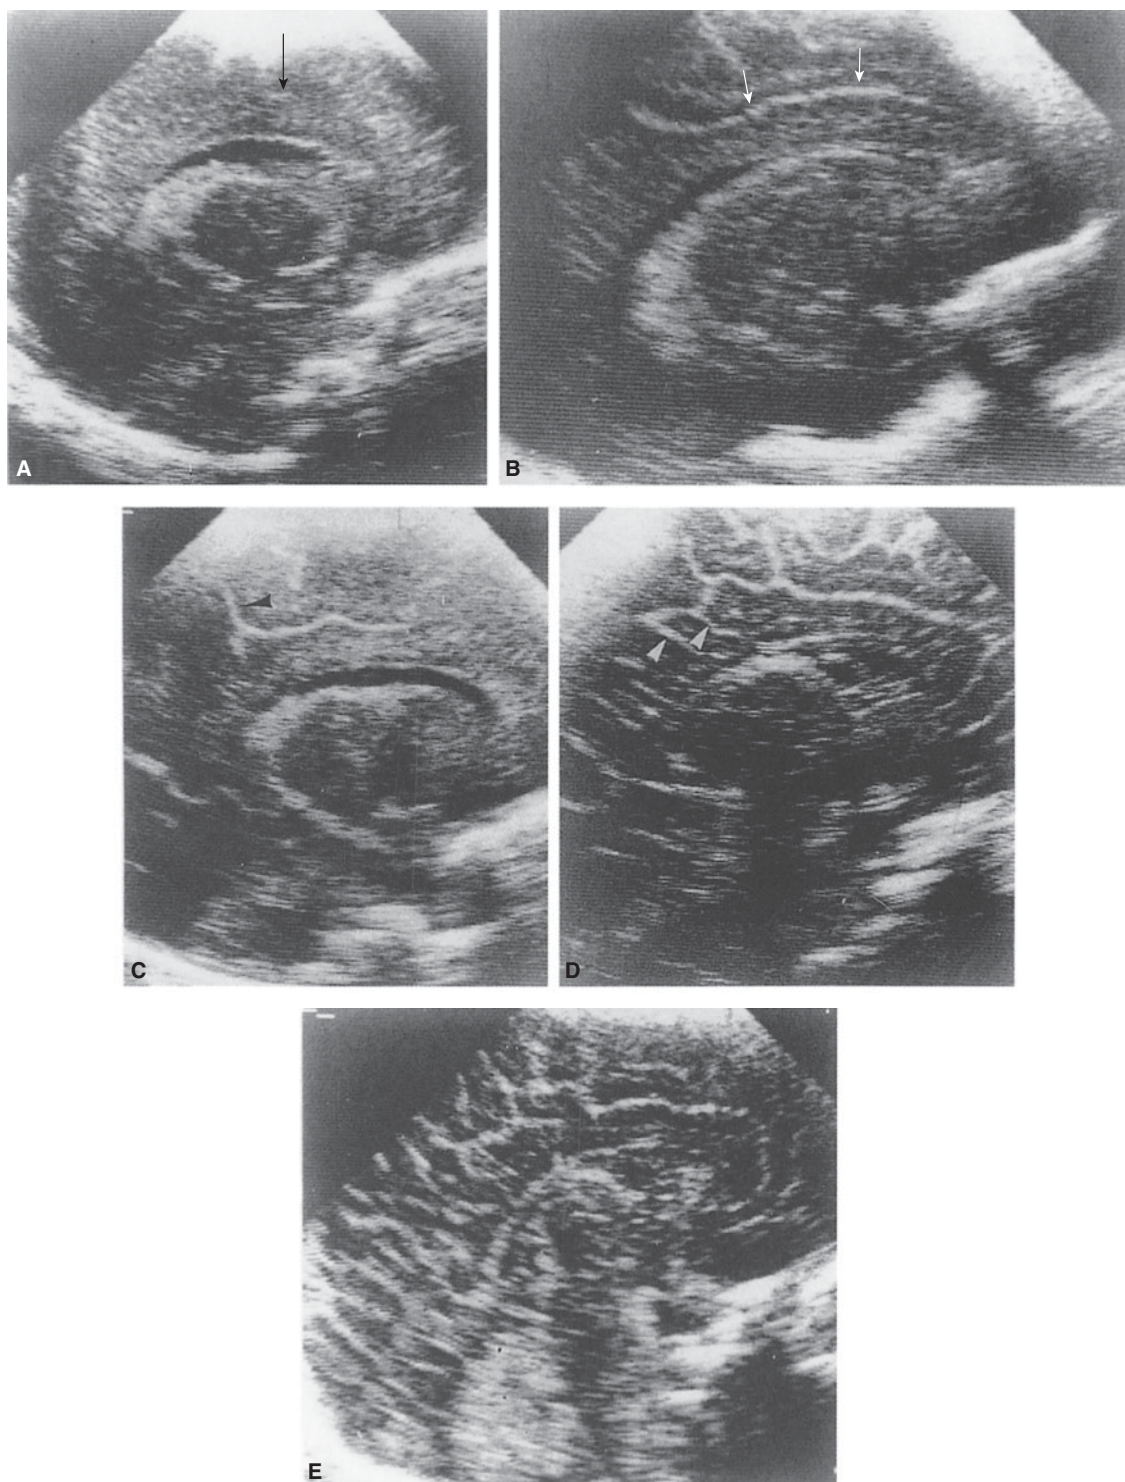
Developmental stages of the cingulate sulcus. Paramedian sonograms demonstrating five developmental stages: (A) The presence of one or more discontinuous linear echoes (arrow); (B) Continuity—a single continuous linear echo (arrows); (C) First branch—perpendicular echo of the primary sulcus (arrowhead); (D) Multiple branches—additional branches off the primary sulcus (arrowheads); and (E) “Cobblestone” pattern branches from the cingulate sulcus, merging with other cortical sulci. (From Slagle and colleagues, 1989,⁹¹ with permission.)
